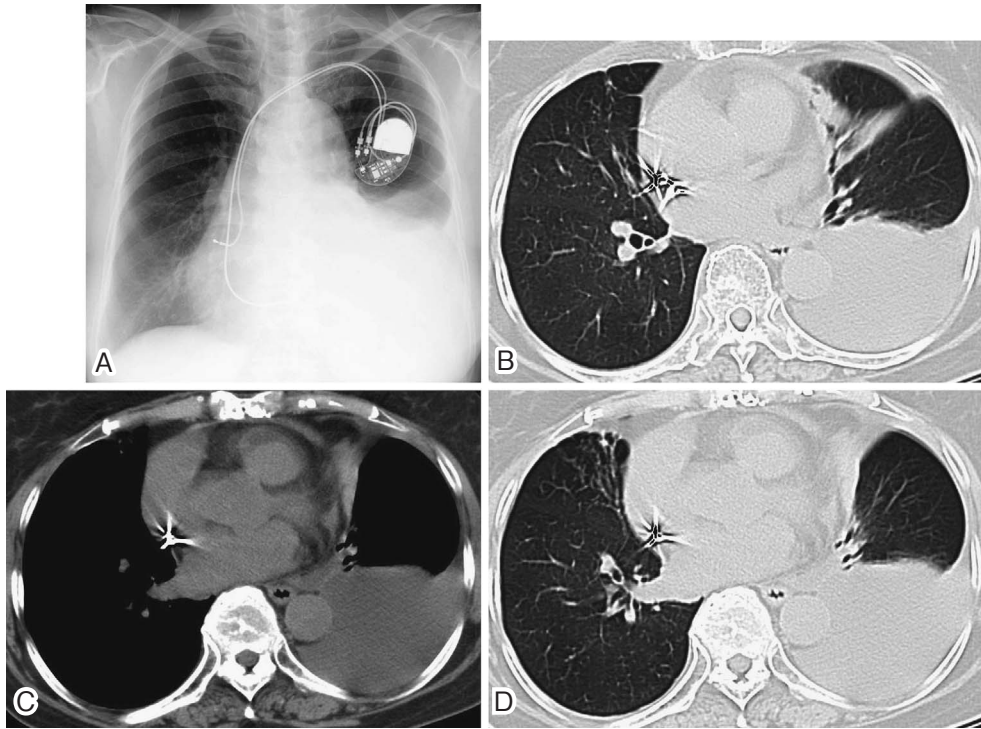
Chest X-ray (A) and computed tomography (CT) (B) images show massive pleural effusion in the left side. Chest CT also shows bronchiectasis and small nodules in the right middle lobe, as well as bronchiectasis and partial atelectasis in the left lingular division (C and D).
